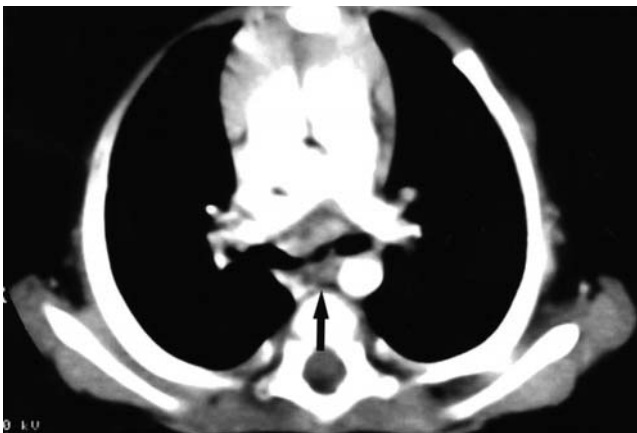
Contrast-enhanced axial CT scan of the chest just below the level of the carina, showing subcarinal adenopathy (arrow).
